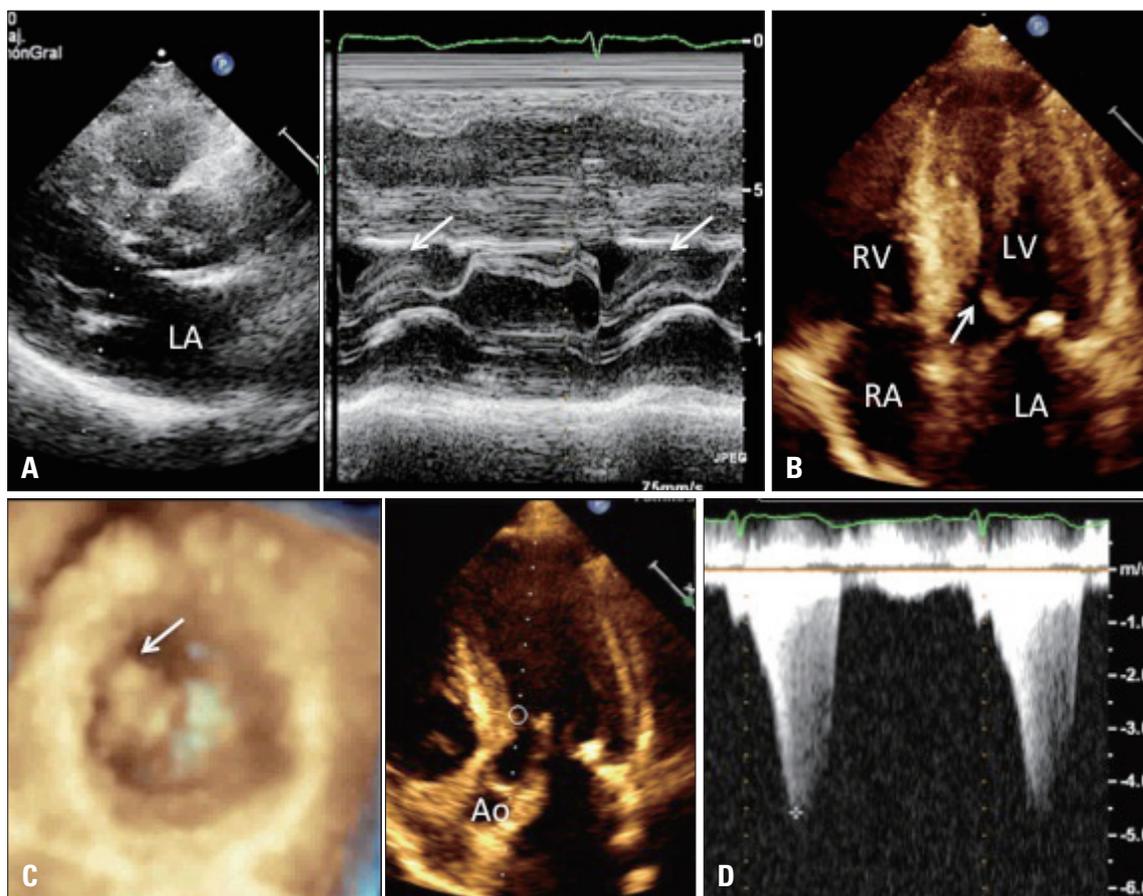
Parasternal long axis view with M mode (A), two-dimensional apical four-chamber view (B), short axis view at the level of both ventricles (C) and apical 4-chamber view with continuous wave Doppler (D), showing systolic anterior motion of the mitral valve with obstruction of the left ventricle outflow tract (white arrows). The characteristic appearance of the late peak is observed as a dagger. LA: left atrium, LV: left ventricle, RA: right atrium, RV: right ventricle, Ao: aorta.
